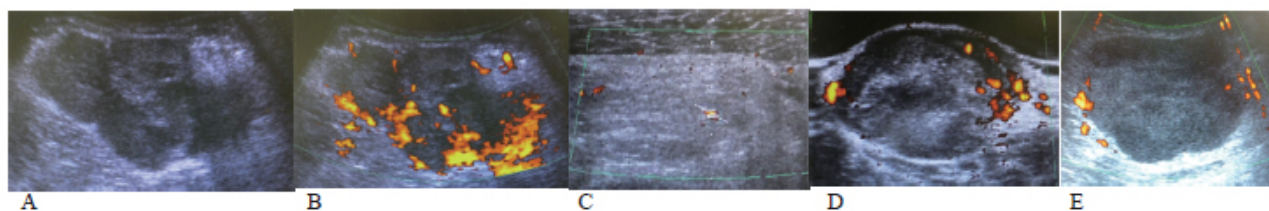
Representative ultrasonography findings of patients in this study. Grade III undifferentiated pleomorphic sarcoma in the thigh (67-year-old man). Hypoechoic, ill-defined, infiltrating margin (A) with prominent vascularization (Giovagnorio's criteria type VI) (B). A score of 4 is assigned, indicating high-grade tumor (true positive). (C.) Grade I well-differentiated liposarcoma in the buttock (52-year-old man). Hyperechoic mass and undefined margin with limited marginal vascularity (Giovagnorio's criteria type III). A score of 1 is assigned, indicating low-grade tumor (true negative). (D.) Grade I dermatofibrosarcoma protuberance in the shoulder (34-year-old man). Hyperechoic, well-defined margin with prominent vascularization (Giovagnorio's criteria type VI). A score of 1 is assigned, indicating low-grade sarcoma (true negative). (E.) Grade III malignant peripheral nerve sheath tumor in the abdomen wall (74-year-old man). Hypoechoic, well-defined margin with limited marginal vascularity (Giovagnorio's criteria type III). A score of 2 is assigned, indicating low-grade sarcoma (false negative).
